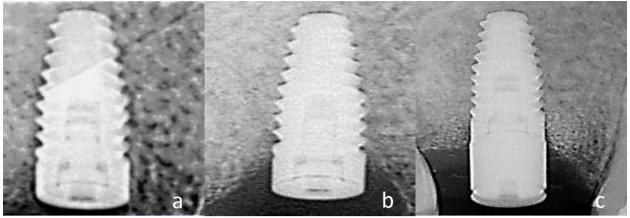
Intra-oral periapical radiographs (patient A) showing the radiological bone level around the implant. a) Immediate post Implant #13 installation; b) evident radiolucency encircling the implant's coronal region; and c) radiological bone fill surrounding the implant 5 months after the surgical treatment.
